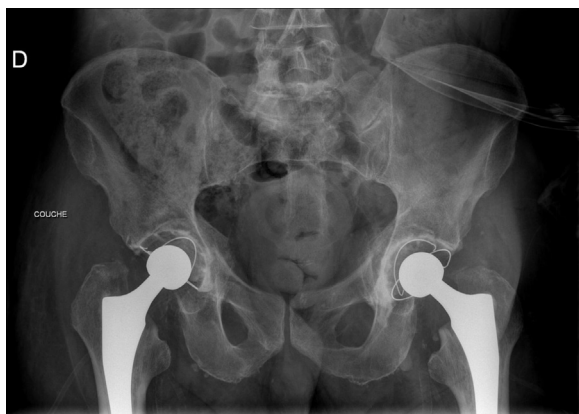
Anteroposterior pelvis post-operative pelvic radiographs demonstrating bilateral total hip arthroplasty.
